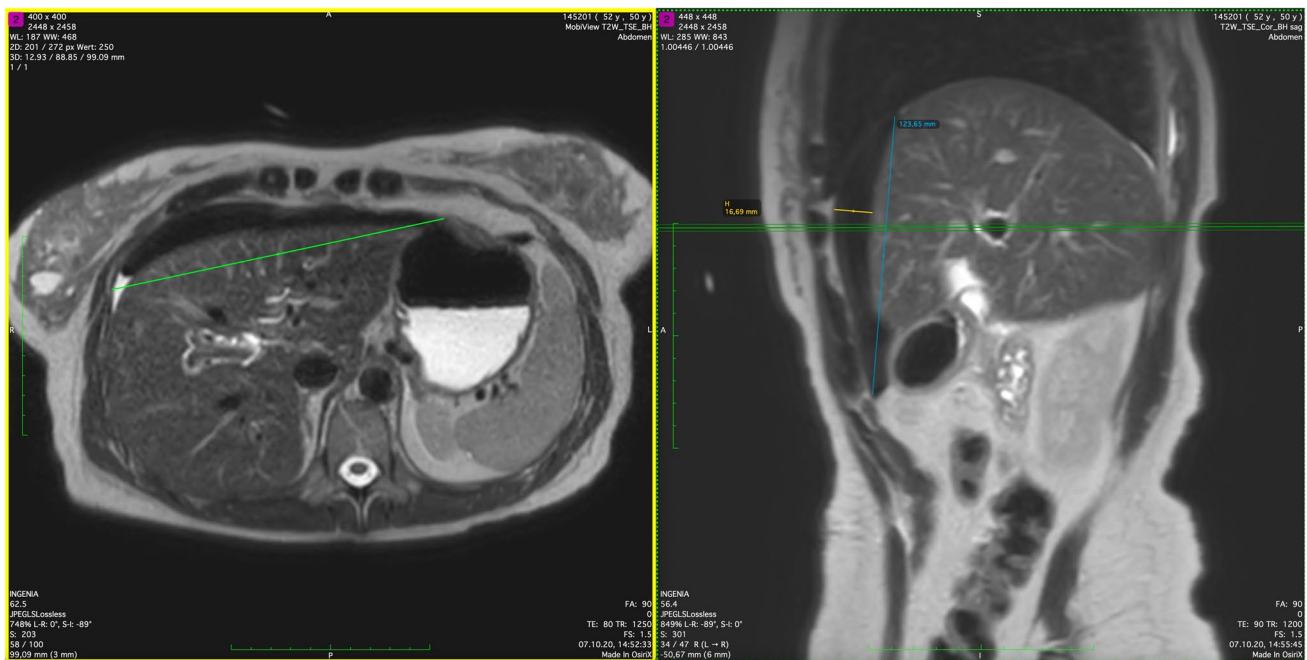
MRI image of free air under diaphragm
